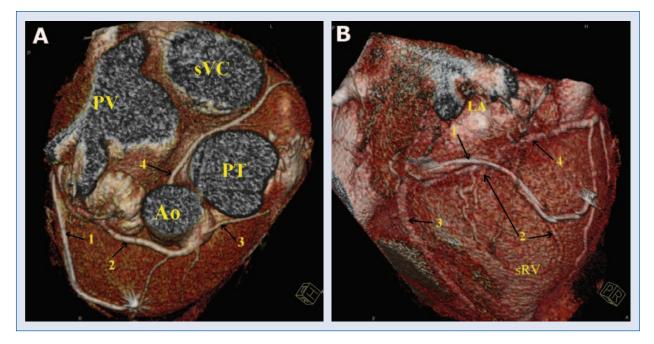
A, B. Multi-slice computed tomography — 3D projection. Coronary arteries and cardiac veins are shown; A. View of the upper part of the heart. Cut-off at the level of great vessels; 1 — coronary sinus with the lead; 2 — right coronary artery; 3 — left anterior descendent coronary artery; 4 — left circumflex coronary artery; Ao — aorta; PT — pulmonary trunk; PV — pulmonary veins; sVC — superior vena cava; B. View of the right lateral wall of the heart; 1 — coronary sinus with the lead; 2 — posterior and lateral branches of coronary sinus; 3 — posterior cardiac vein; 4 — right coronary artery; sRV — systemic right ventricle; LA — left atrium.
